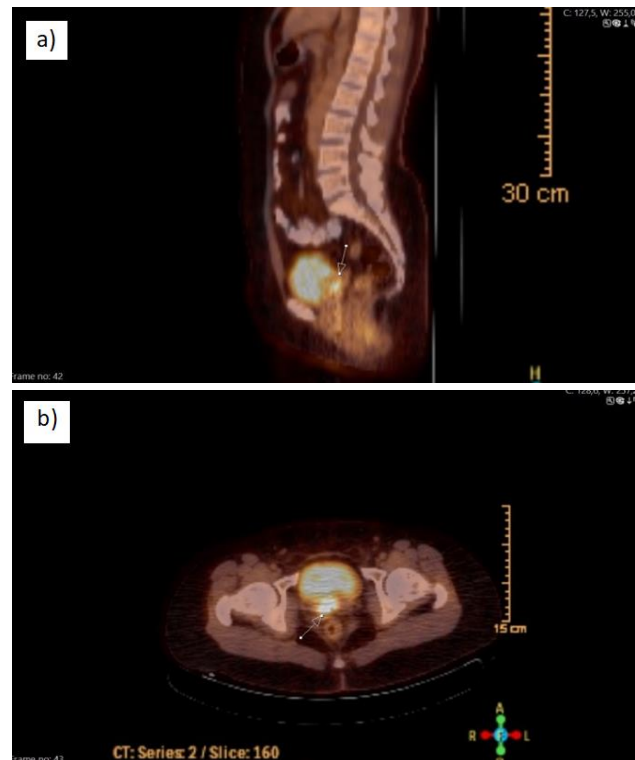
(a, b). Tumoral mass at the upper vagina in PET-CT
